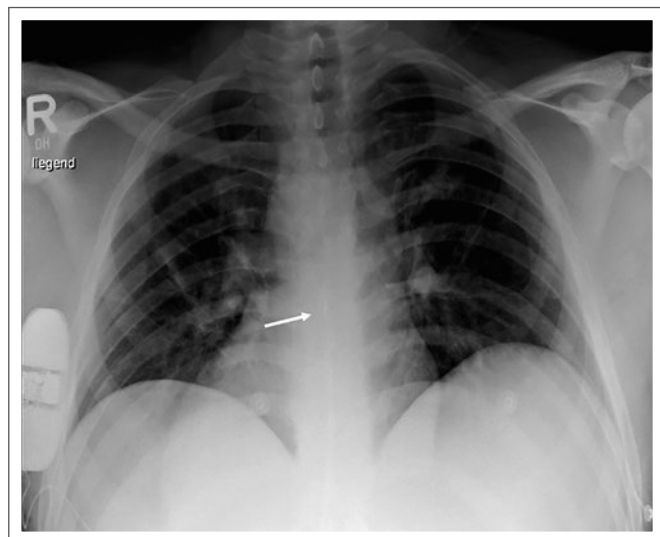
Chest x-ray p. a. view in supine position. Dextrocardia *situs inversus* with right-sided S-ICD in position.
